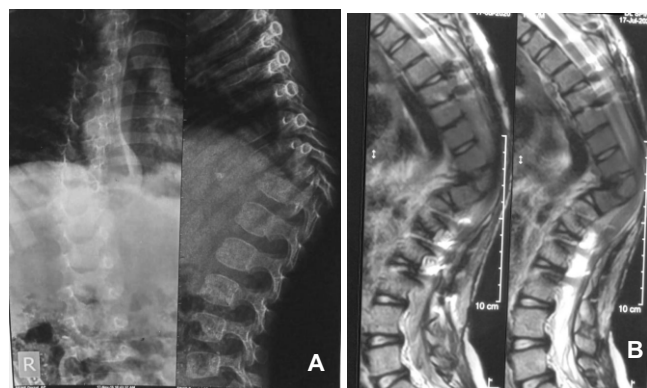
(A): Plain radiograph of a 4 year old male child with mid-dorsal Tuberculosis of spine (D7-D9) with severe collapse of D8 vertebra with gibbus formation (B): MRI of the same child confirming collapse and gibbus formation with large epidural abscess formation
